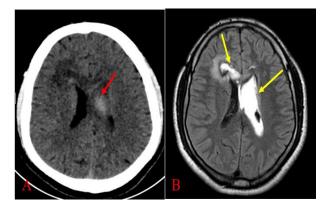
(A and B): Axial NCCT image and T1 axial MRI image showing right intraparenchymal haemorrhage with intraventricular extension.
